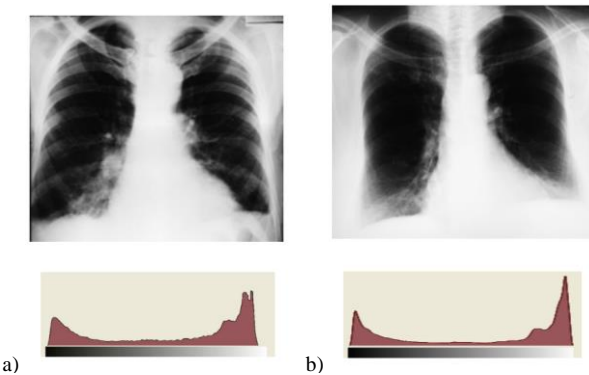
Examples of overexposed X-rays and their histograms.
